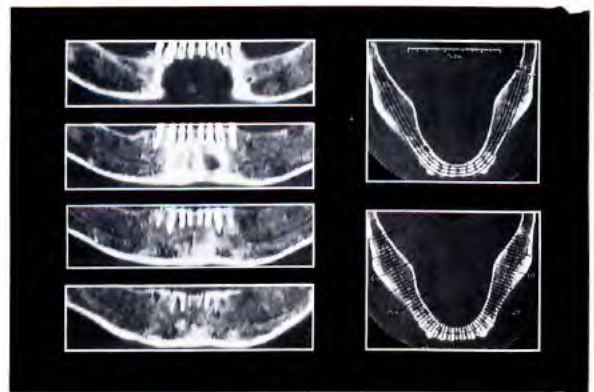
Panoramic image is another of the three images reformatted by the CT scanner.
